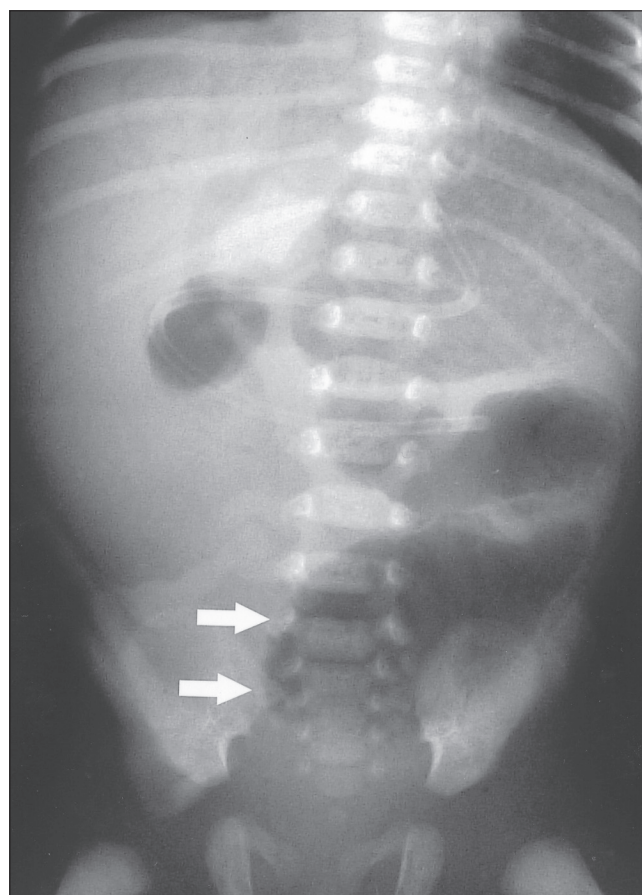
Admission supine abdominal radiograph, showing a short segment of grossly distended proximal small bowel (arrows) and no distal bowel gas. Features are consistent with high jejunal atresia.
